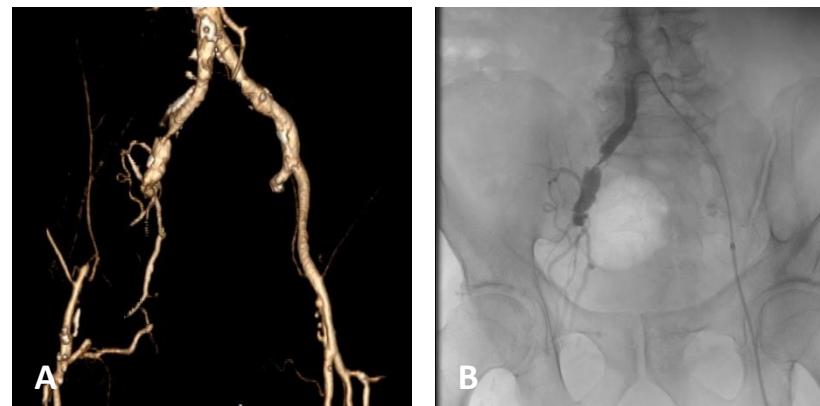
(A) 3D CT-angiography before surgery. (B) Intraoperative angiography.
